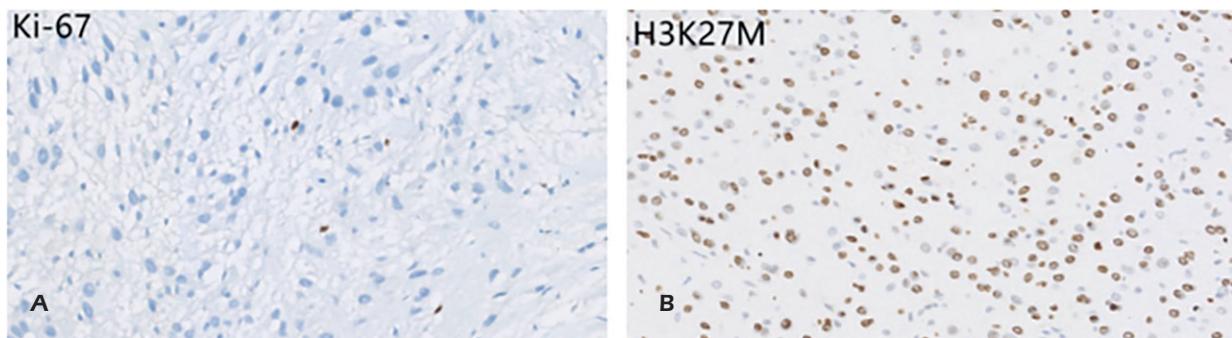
A, B, Glioblastoma (grade IV), Ki67 50%. IDH1, IDH2 gene, and TERT gene promoter mutation were not detected by gene detection, MGMT gene promoter methylation was not detected. The patient recovered well after surgery, and reexamination of MRI showed relevant changes after the surgery.
